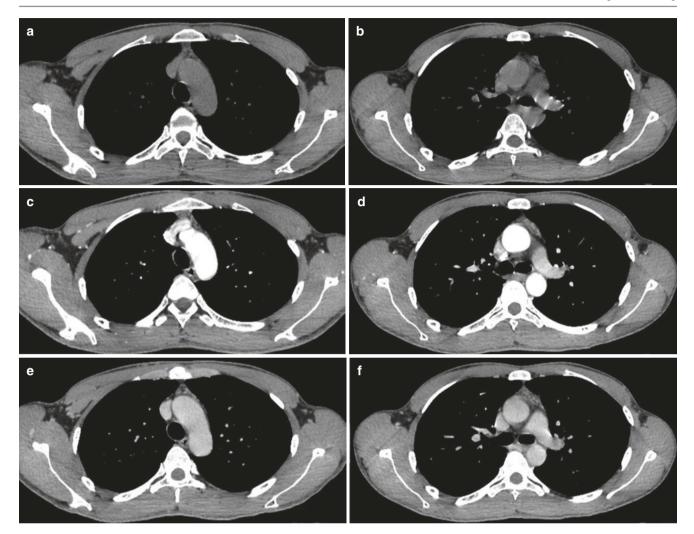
(a–f) Chest CT image of a 26-year-old man
